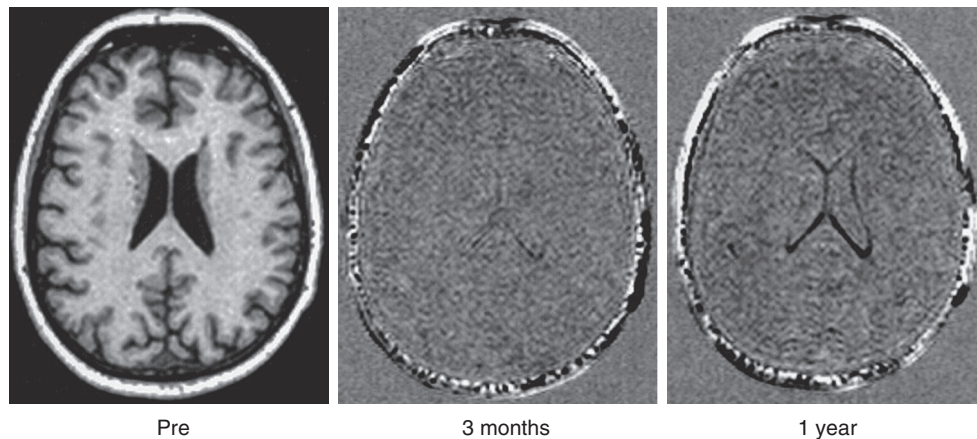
■ Preoperative brain MRI from patient undergoing extensive cardiac surgery superimposed on identical images taken at 3 months and 1 year after surgery. The appearance of the ventricles at 1 year indicates brain shrinkage, presumably from apoptosis of neurons.
